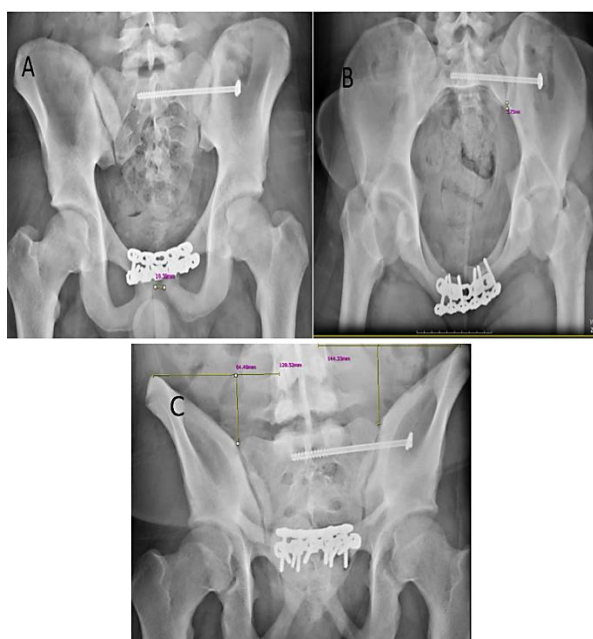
Pelvic radiographs of a 51-year-old woman demonstrating the injury pattern on standard views: A) Anteroposterior (AP); B) Inlet; and C) Outlet
